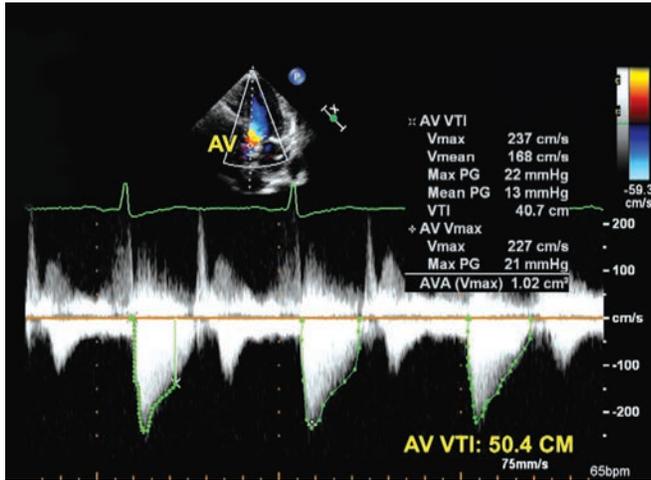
Apical five chamber view. Continuous wave Doppler examination of the AV.
